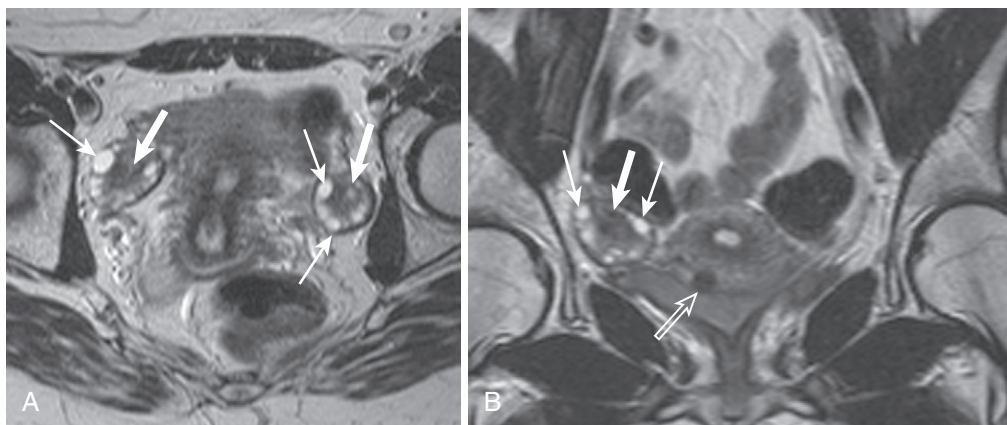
Normal ovaries. Normal ovaries averaging 10 cc in size with subcentimeter ovoid, peripheral subcentimeter follicle cysts (*thin arrows*), and central stroma (*thick arrows*) are easily identified when noting these typical characteristics, as exemplified on the axial (A) and coronal (B) T2-weighted images. A small, partially subserosal fibroid protrudes from the anterior uterine body (*open arrow* in B).
